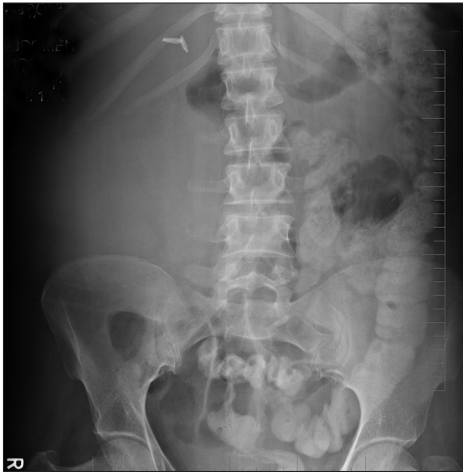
Digital X-ray KUB showed a large soft tissue density in right lumbar region with loss of right psoas shadow, blurring of preperitoneal fat planes, displaced bowel loops and mild scoliosis of spine
